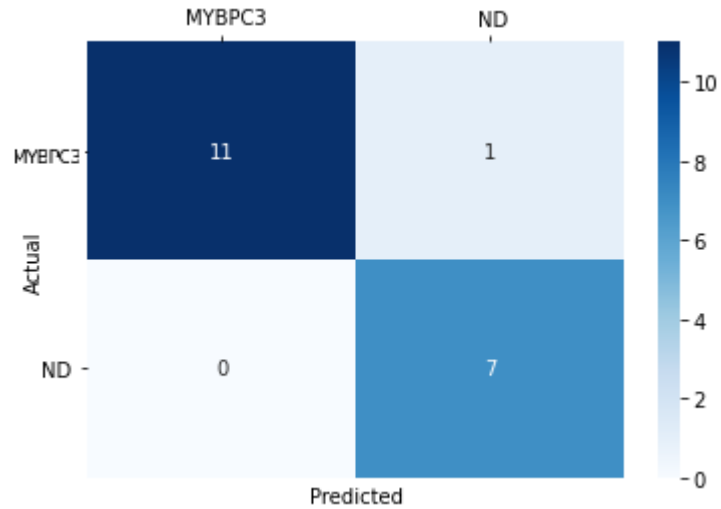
Confusion matrix, model for echocardiographic images classification (*MYBPC3* vs. ND), apical 2-chamber view during ventricular systole
